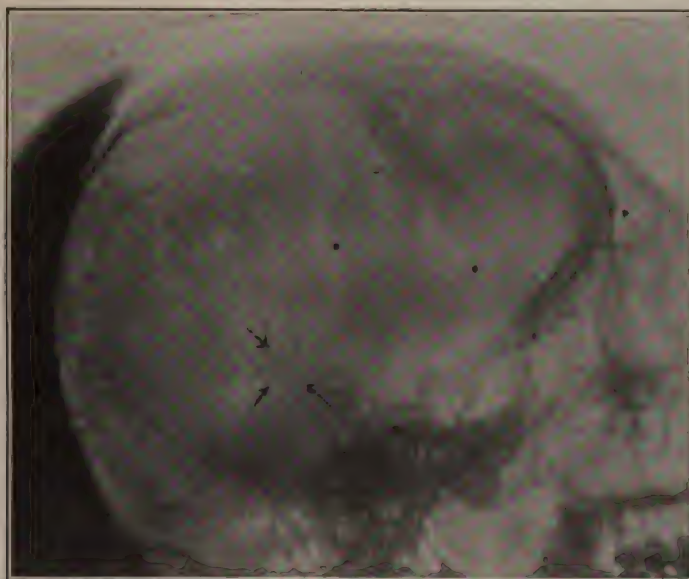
Calcified Pineal Gland. (X-ray Dept., J. H. H.)
